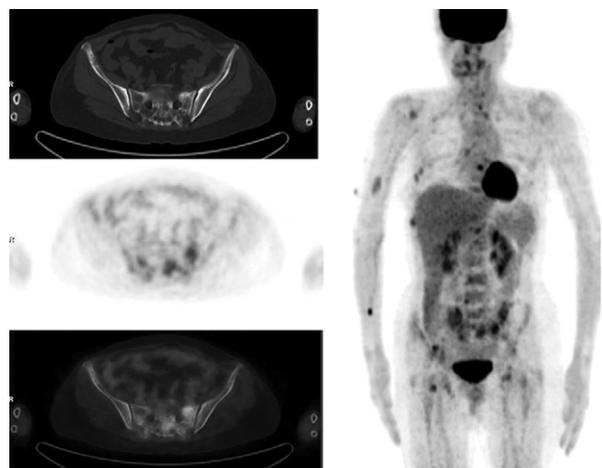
FDG PET/CT was performed as a part of staging before treatment in a 56-year-old female patient with breast carcinoma. Multiple bone metastases with increased FDG uptake (SUVmax: 9.78) were shown.
